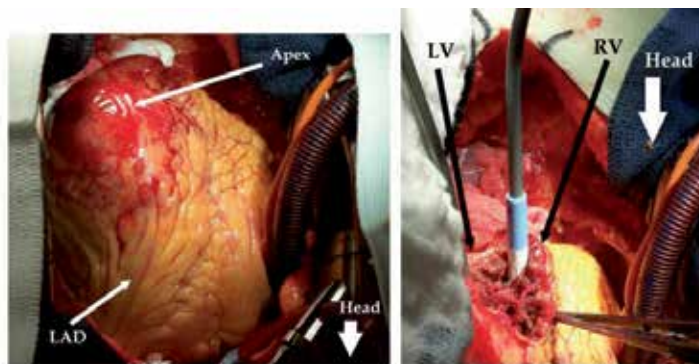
Left: Intra-operative view of the extensive apical infarction that has resulted in the echocardiographic findings demonstrated in Figure 2. The left anterior descending artery (LAD) is shown. Right: The same patient after opening and debridement of the infarcted apex. The necrotic septum is visualized with a probe in the left ventricle (LV) and the bypass "pump sucker" is in the right ventricle (RV).
